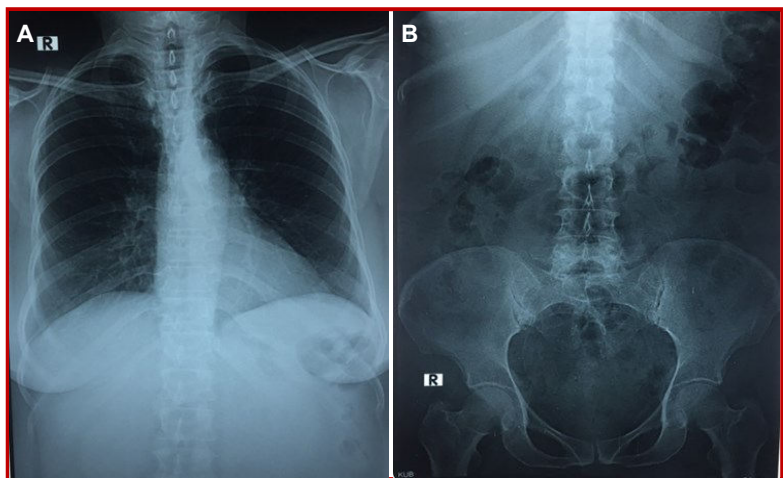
Chest x-ray in erect posture PA view shows no free gas shadow (A); X-ray KUB region (B)
